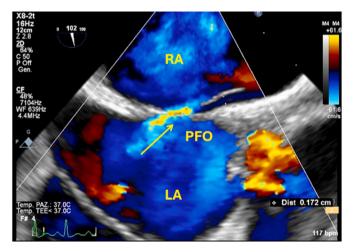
A transesophageal echocardiogram of a 16 year old girl with a branch retinal artery occlusion in the left eye shows blood flow (arrow) through a patent foramen ovale (PFO) with a shunt from left atrium (LA) to right atrium (RA).
